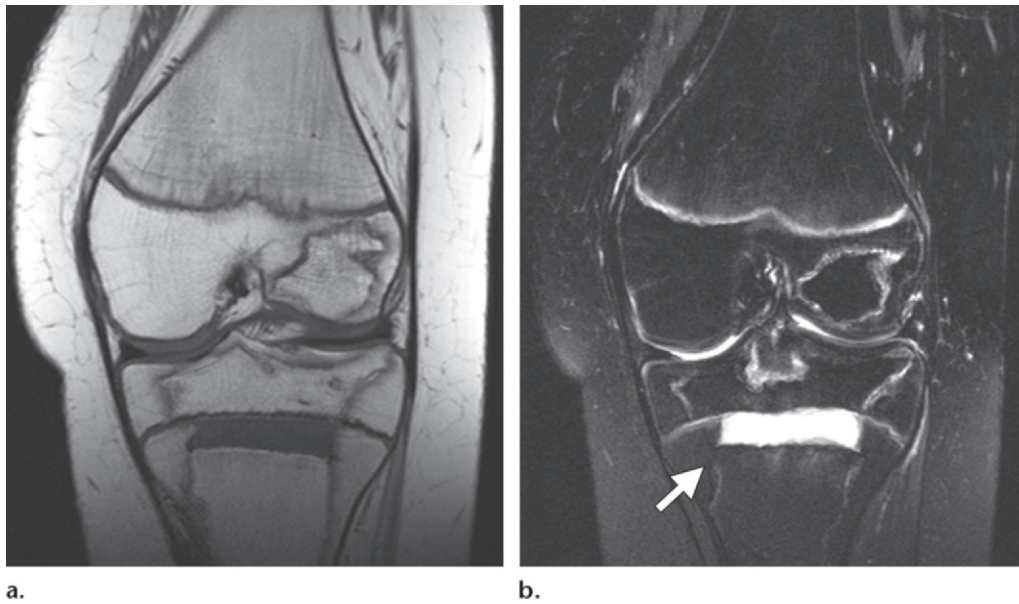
Avascular necrosis of the knee in a 13-year-old female adolescent after chemotherapy for acute lymphoblastic leukemia. (a) Coronal T1-weighted MR image shows serpiginous areas of low signal intensity in the distal femoral epiphysis, proximal tibial epiphysis, and tibial metaphysis. A low-signal-intensity rim delineates the areas of infarct. The ZPC in the central region of the femoral physis appears effaced and eventually developed a bridge (not shown). (b) Coronal T2-weighted MR image shows high-signal-intensity serpiginous rims. A front of unmineralized cartilage that starts in the physis and extends into the tibial metaphysis (arrow) is due to disrupted endochondral ossification.
